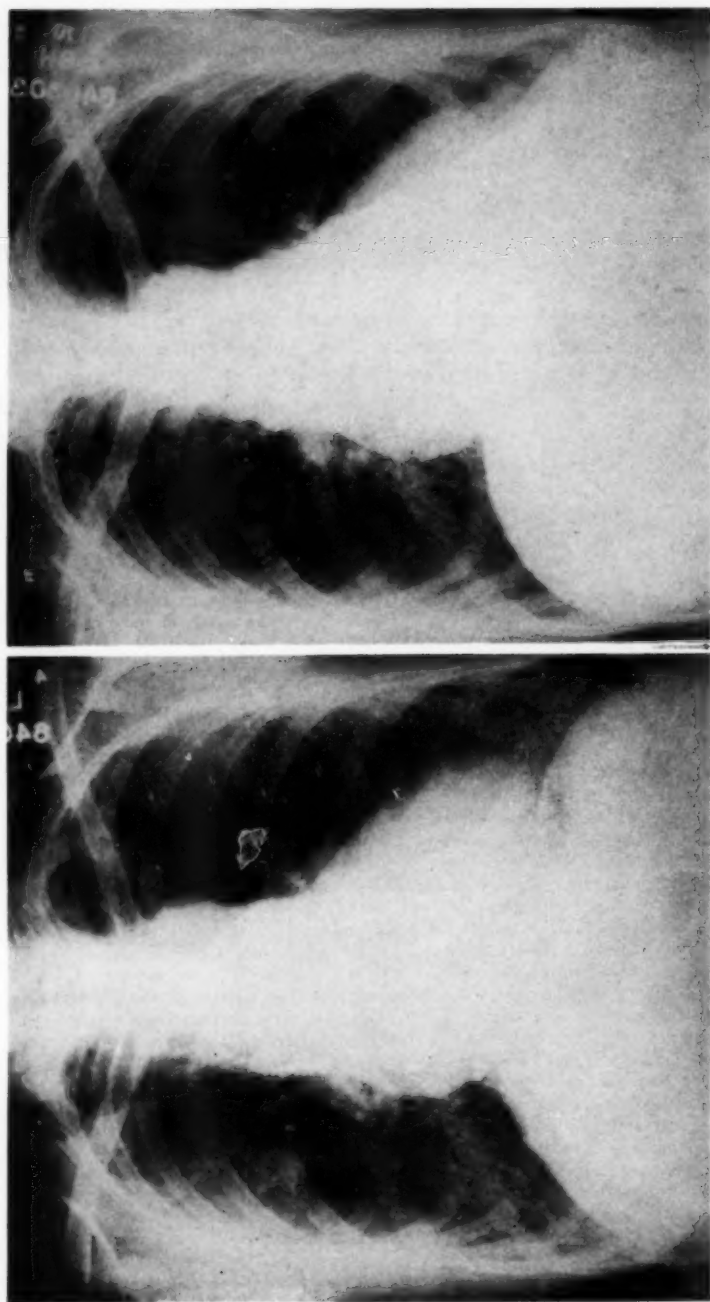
(left). Case 2. Admission chest roentgenogram. Cardiac shadow and aortic knob are prominent. Bronchovascular markings are increased, and an ill-defined fleecy infiltration is seen in each second intercostal space.
